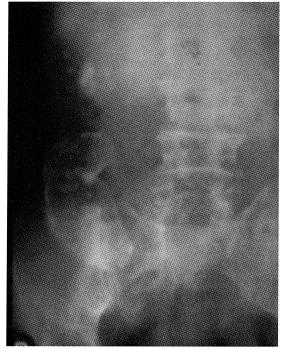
Plain abdominal radiograph. Note the tubular mass in the right lower quadrant with curvilinear wall calcification and some clusters of small rounded calcific densities within. Incidental right renal calculi are also present.
